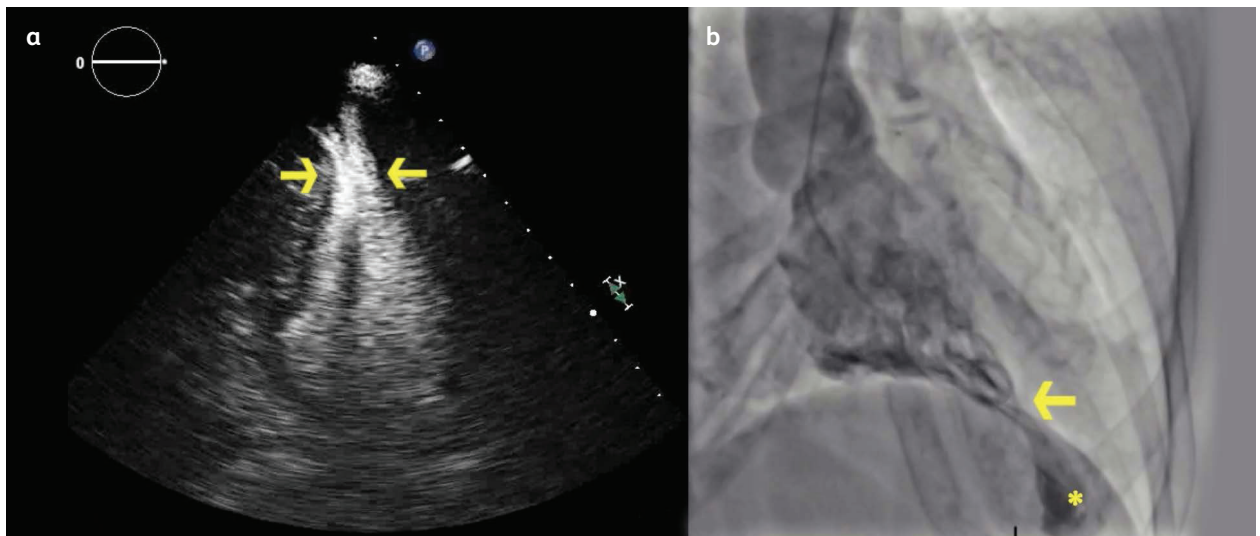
a) Transthoracic echocardiography with contrast showing midventricular narrowing of the left ventricle. b) Left ventriculography showing midventricular narrowing and 'hourglass' appearance of the left ventricle. Asterisk points to the apical aneurysm.
